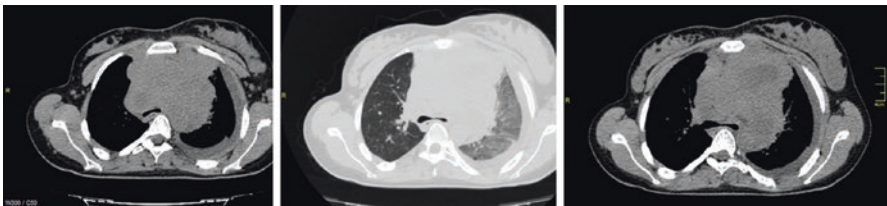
Chest CT without contrast: non-Hodgkin lymphoma B-cell. It is observed hypodense and inhomogeneous mass occupying the mediastinum
